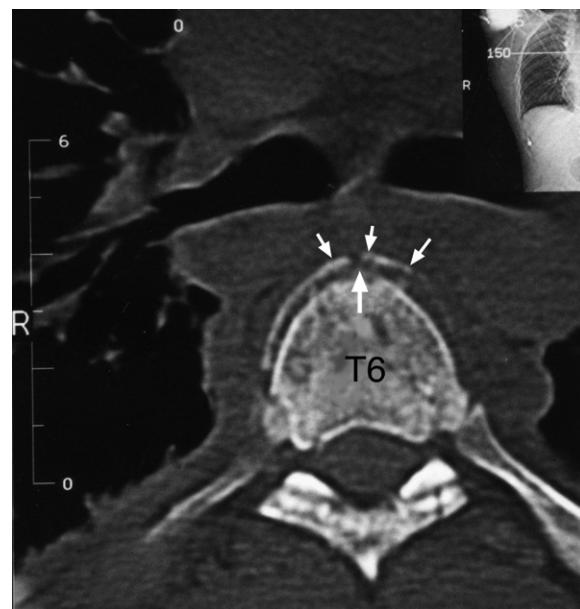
Thoracic spine CT axial image at the T6 vertebral body level. Note the bursting fracture anteriorly at this level (white arrows).
